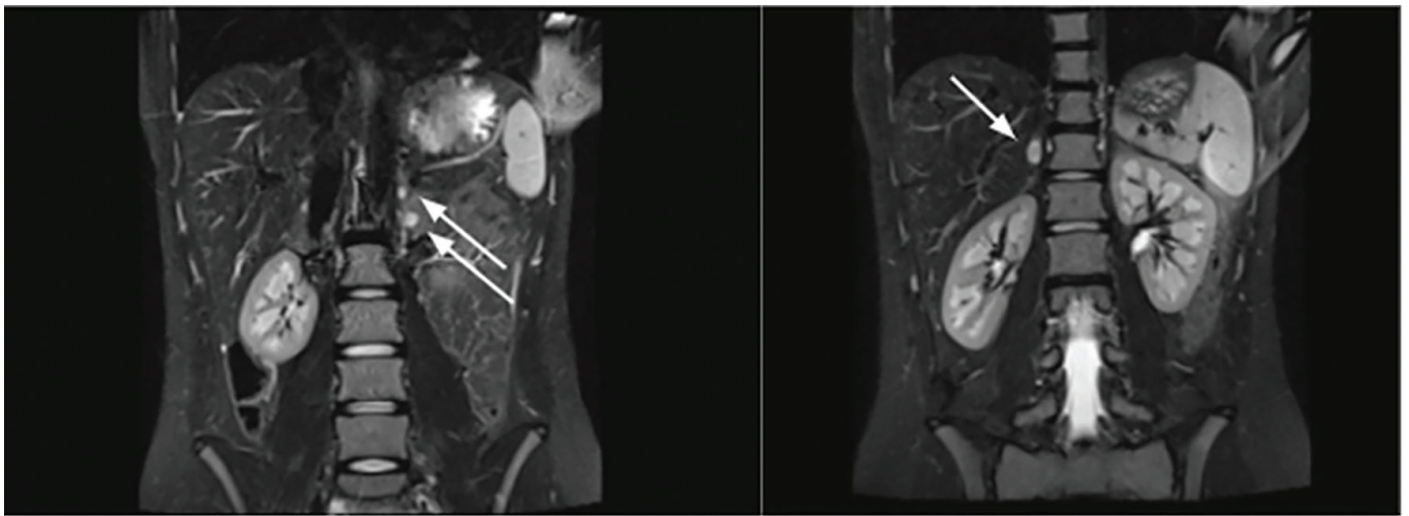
MRI of the abdomen, Patient 4- a lesion in the upper part of the right adrenal gland (arrow) approx. 11x 9 mm ax x 13 mm cc, and in the lower part, size 5 mm, also within the left adrenal gland, small nodules with features of contrast enhancement, size up to 7 mm
